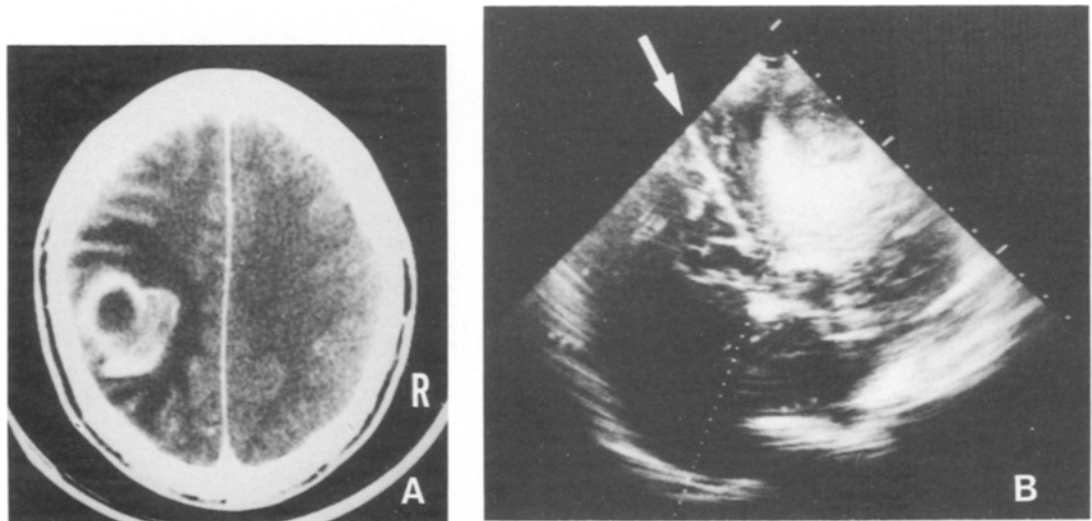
49-year-old male with a brain abscess. (A) Enhanced computed tomography scan shows a ring enhancement with medial bulging. (B) Coronal-cut ultrasonograph through a parietal burr-hole shows a cystic mass. The dotted guideline is set to pass through the second burr-hole as well as through the target. Pus is then aspirated using a ventricular needle passing through the needle-guide. *Arrow* indicates interhemispheric fissure
